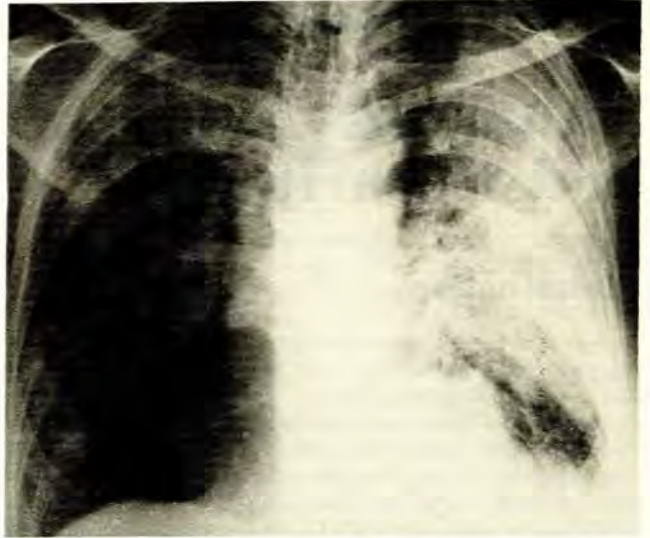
Chest radiograph showing consolidation of the left upper lobe and perihilar region with patchy shadowing in the right lung.
